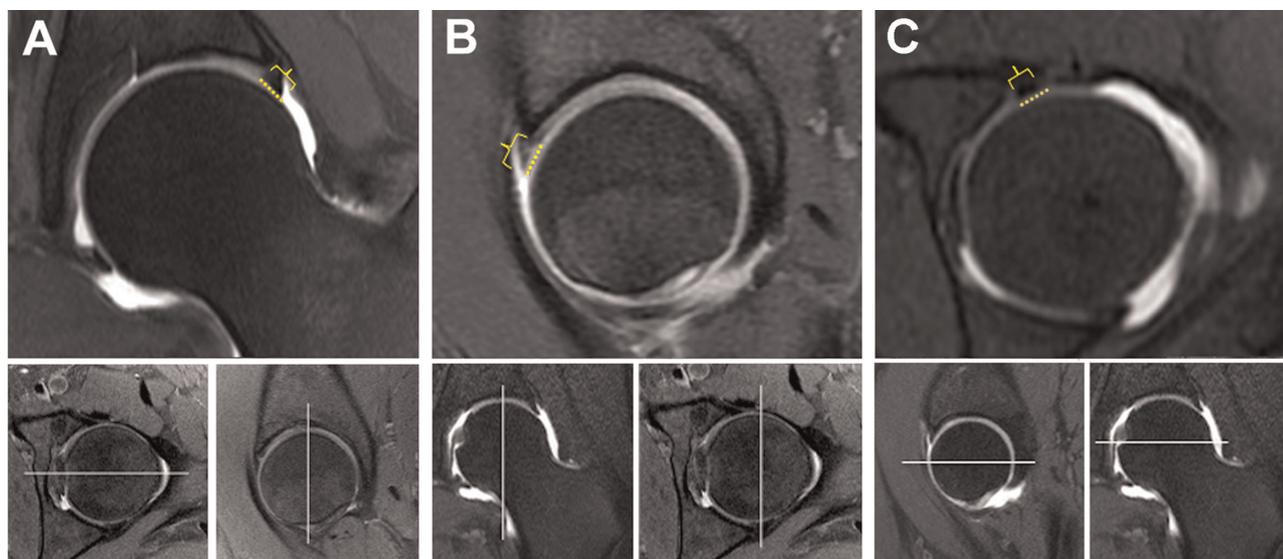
(A) Lateral labral length measurement technique on coronal magnetic resonance imaging (MRI) utilizing a fat-saturated proton density (FSPD) sequence. The lateral labrum is defined as the labrum at the level of the central coronal MRI scan cross-referenced to the axial and sagittal planes (insets). The dotted line and bracket denote the length of the lateral labrum from the acetabular rim to the free edge. (B) Anterior labral length measurement technique on sagittal MRI utilizing an FSPD sequence. The anterior labrum is defined as the labrum at the level of the central sagittal MRI scan cross-referenced to the axial and coronal planes (insets). The dotted line and bracket denote the length of the anterior labrum from the acetabular rim to the free edge. (C) Anteroinferior labral length measurement technique on axial MRI utilizing an FSPD sequence. The anteroinferior labrum is defined as the labrum at the level of the central axial MRI scan cross-referenced to the sagittal and coronal planes (insets). The dotted line and bracket denote the length of the anteroinferior labrum from the acetabular rim to the free edge.
